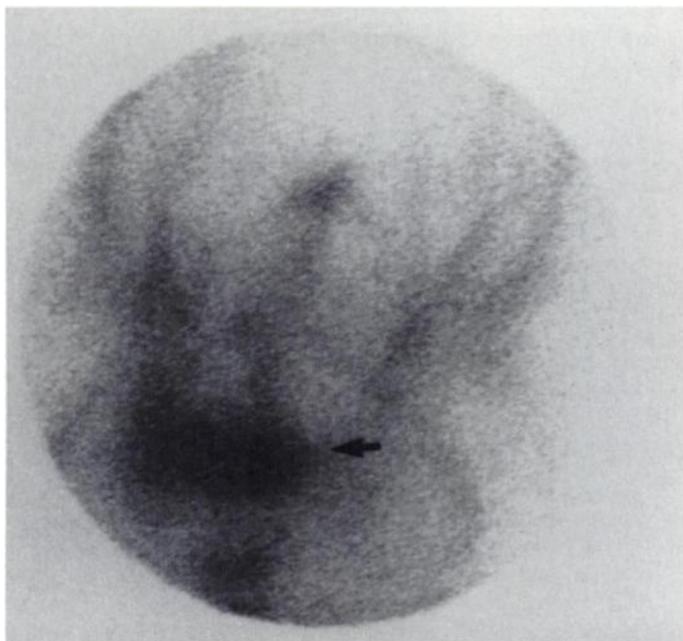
Cervical carcinoma was diagnosed in this 72-yr-old woman. Surgery was unsuccessful and radiotherapy was administered. After 3 mo, fever and abdominal pain developed. Abdominal US revealed a tumor consistent with abnormal uptake in the lower abdomen on ^{111}In -IgG scintigraphy. Laparotomy and culture revealed a pelvic abscess caused by *Peptococcus* spp. After surgery and antibiotic therapy, she recovered and her fever resolved (Patient 5).
